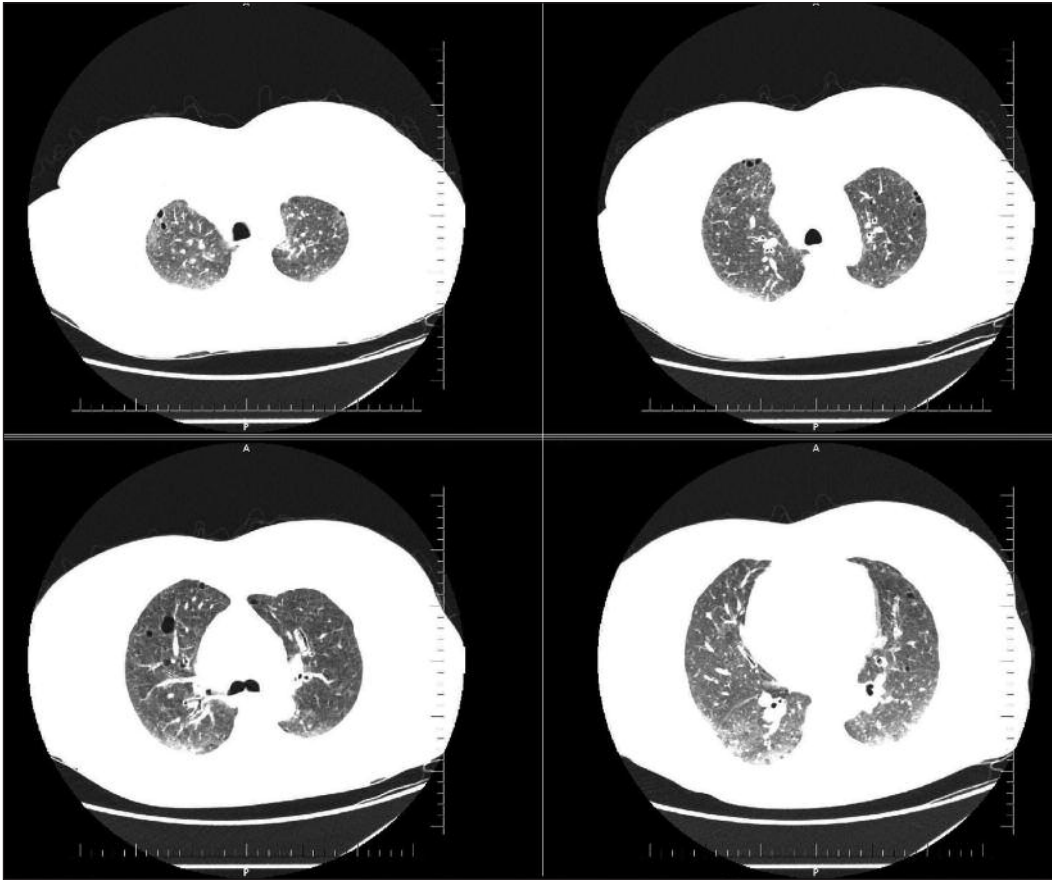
HRCT scan demonstrated bilateral thin walled air cysts with upper lobe predominancy.
